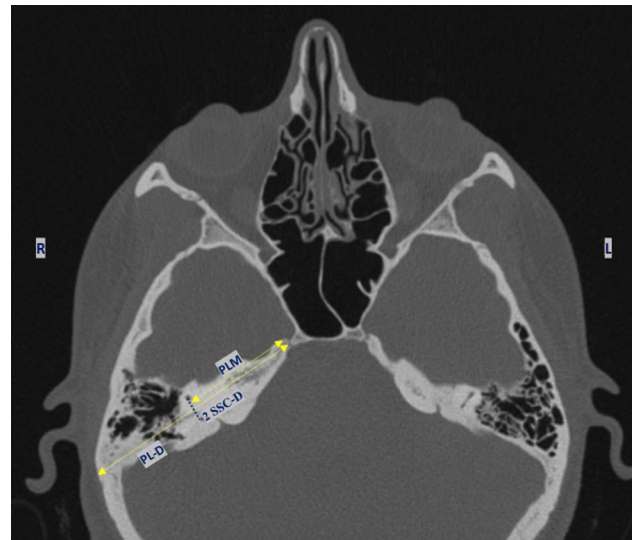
CT scan of the cranium. *SSC-D* The distance between the two arms of the superior semicircular canal, *PLM* Length of the petrous part of the temporal bone medial to the anterior semicircular canal measured from the apex to the SSCD. The measurement was perpendicular to anterior semicircular canal diameter, *PL-D* Length of the petrous part of the TB measured from the apex to the external table of the temporal bone. The measurement was perpendicular to anterior semicircular canal diameter
